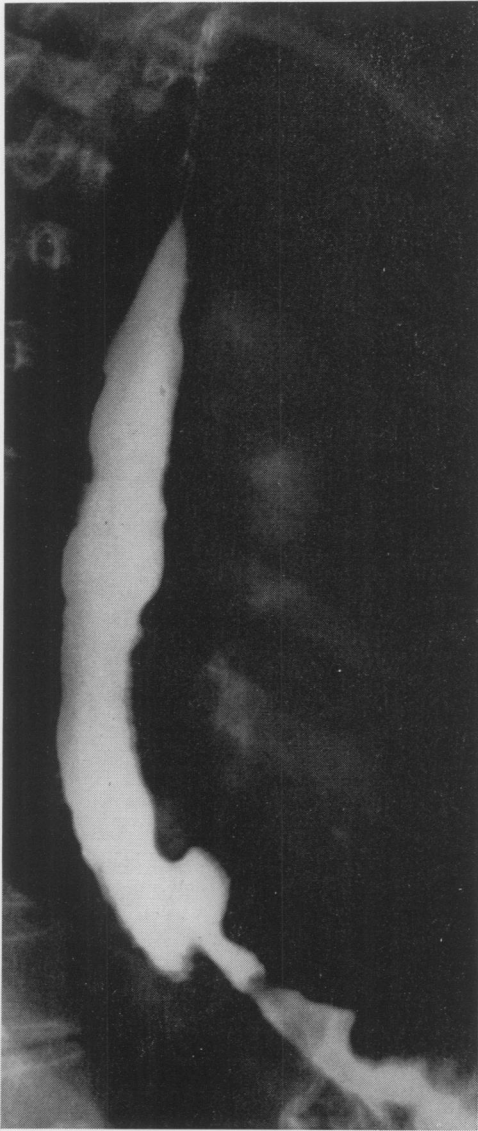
Postoperative roentgenogram made eight months after Heller operation. Gastro-esophageal area is normally distensible, but there are two pseudo-diverticula of distal esophagus with an esophageal ulcer between them.
